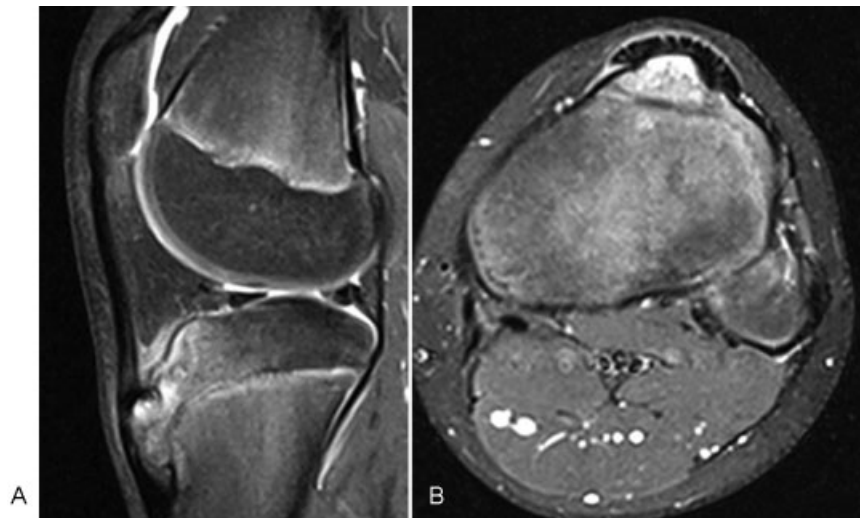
Magnetic resonance image of the 14-year-old patient (case 2): (A) Sagittal scan; (B) axial scan.
